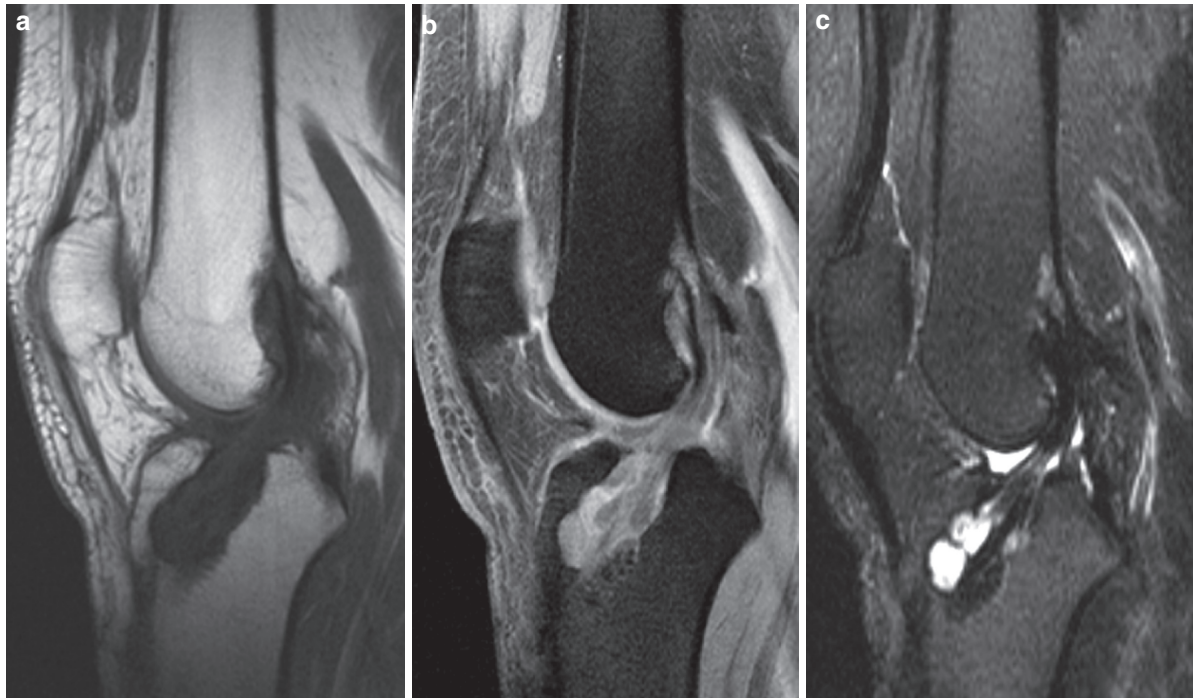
A 38-year-old male presented with a history of continuous chronic anterior left knee pain with daily living activities refractory to conservative treatment. The patient underwent an endoscopic ACL reconstruction 5 years before using autogenous hamstrings tendons fixed with bioabsorbable polylactic acid interference screws. An MRI showing an osteolytic tibial cyst in the tibial tunnel. (a) Sagittal FSE T1 weighted. A hypointense
